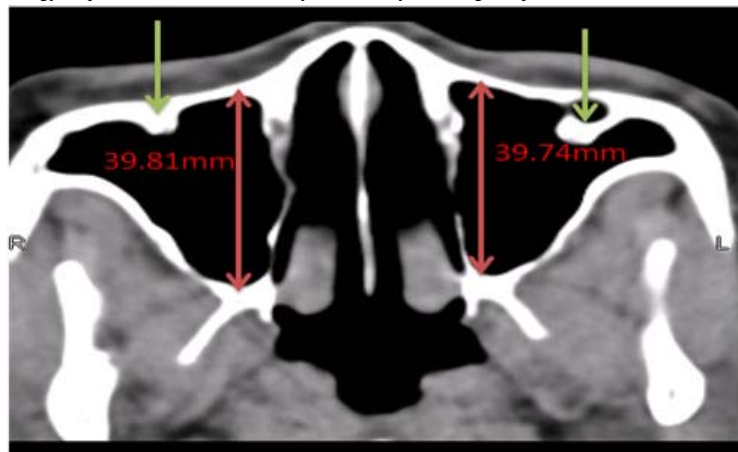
Axial CT of a 45 year of Male Showing Measurement of the Anteroposterior (Depth) Diameter (AP). The Right and Left AP Diameters were 39.81mm and 39.74mm respectively. The Arrows Point towards Septa on the Anterolateral Sinus Wall. R= Right side, L= Left side
